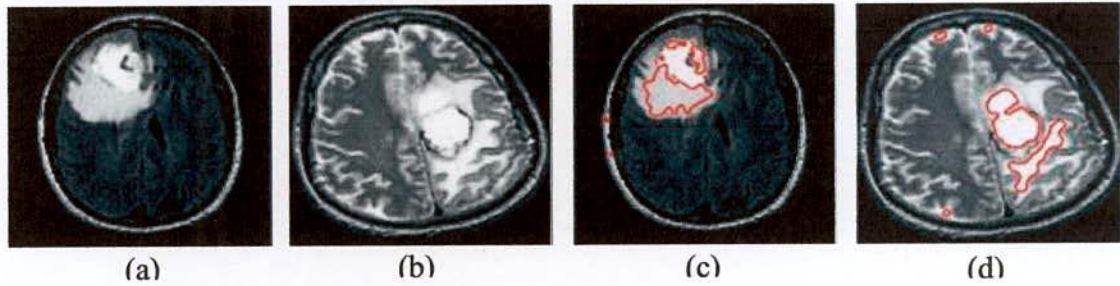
FCM based Brain MRI tumor detection (a, b) Original Brain MRI image and (c, d) FCM based segmented image.
